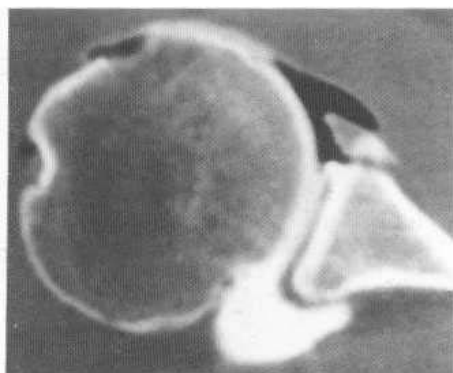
CT arthrotomography showing a labral and glenoid fracture.
